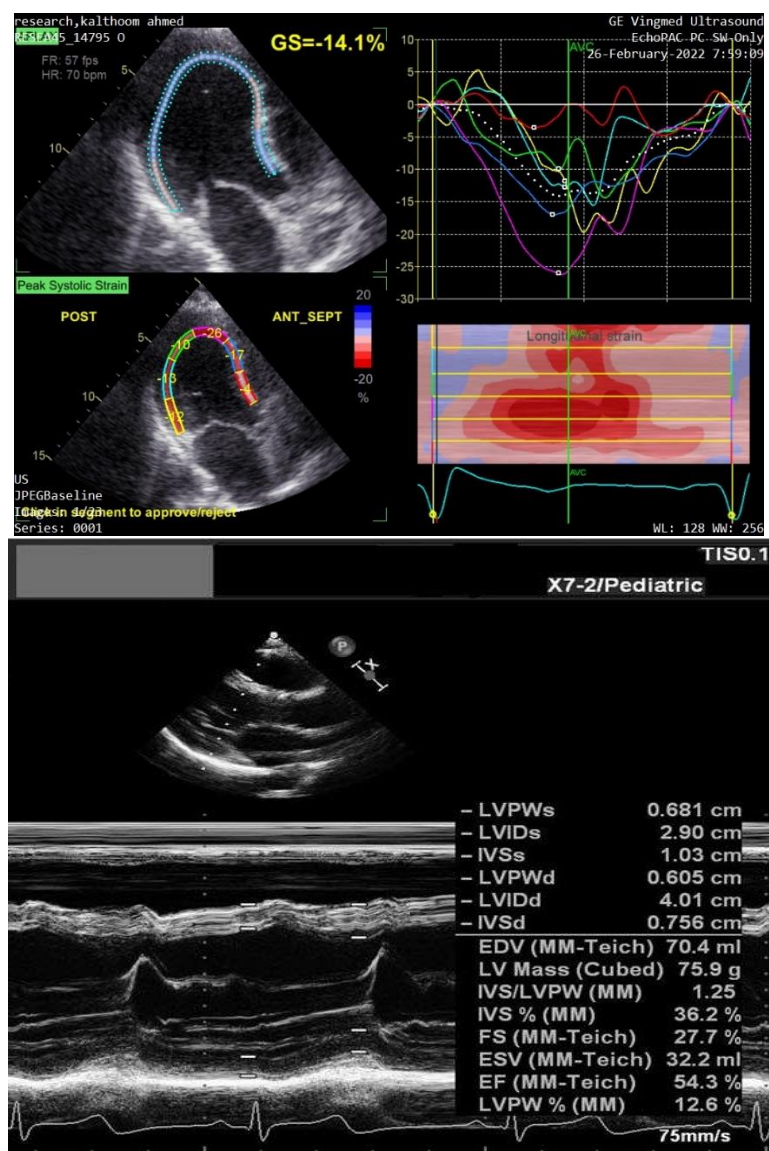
2D and Speckle tracking echocardiography
